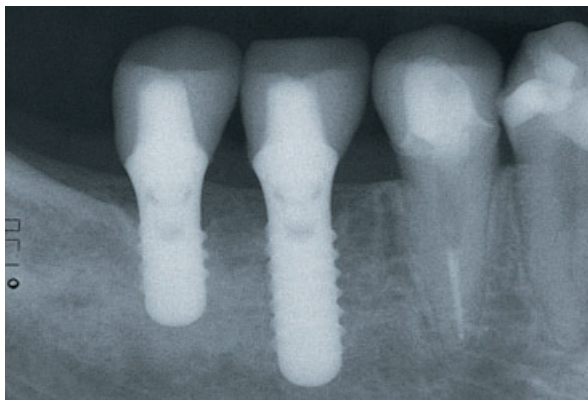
The 1-year radiographic follow-up displays sufficient radio-opacity of the all-ceramic substrate to evaluate the marginal adaptation of the three single-unit restorations.
